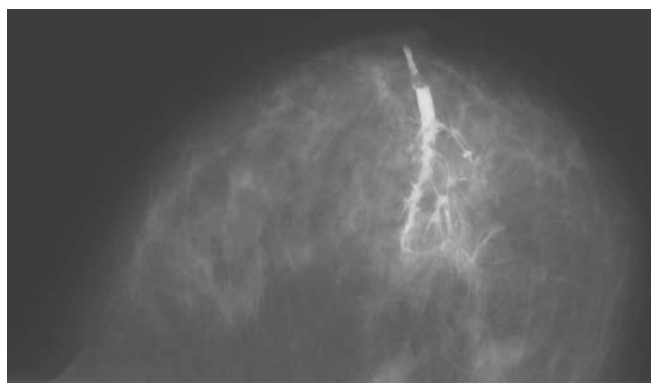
Bloody nipple discharge. No pathology on the plain mammogram or on ultrasound. Irregular contour of duct, partially non-filling, distortion of architecture characteristic of intraductal growth of a carcinoma. Pathology: non-invasive duct carcinoma
